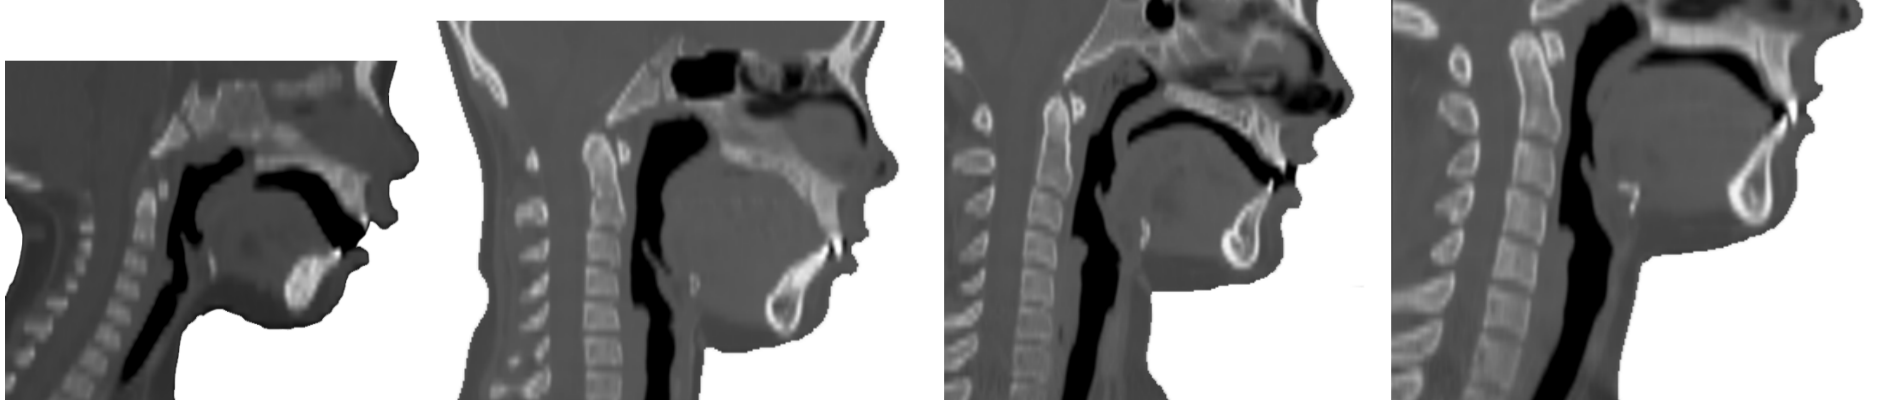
CT scans of from a 1 year old, 9 year old, 13 year old and 19 year old sequentially.
